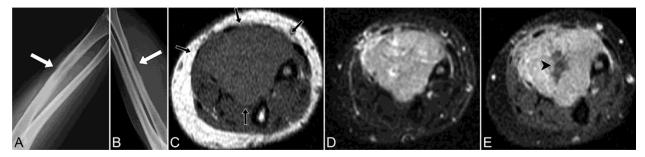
Undifferentiated pleomorphic soft tissue sarcoma with bone erosion in right forearm of a 57-year-old man. AP (A) and lateral (B) radiographs of the right forearm with superficial cortical erosion at mid radial shaft (arrows). The soft tissue mass is isointense to muscle on axial T1-WI (C), heterogeneously hyperintense on axial fat-suppressed (FS) T2-WI (D) and demonstrates heterogeneous enhancement with central necrosis (arrowhead) on axial postcontrast FS T1-WI (E).
